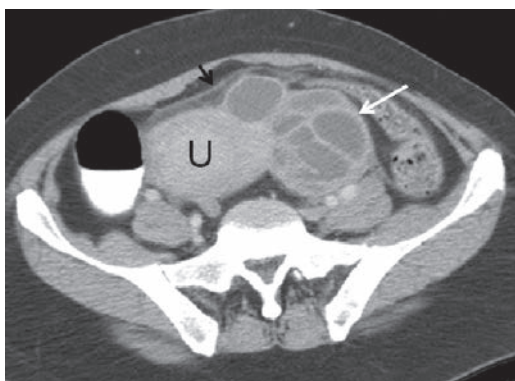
A 40-year-old woman with cervical cancer presented with fever, left lower quadrant pain and diagnosed with tubo-ovarian abscess. Axial contrast enhanced CT scan demonstrates a complex multiloculated mass with thick septations (white arrow) to the left of the uterine fundus (U). There are inflammatory changes in the pelvic fat (black arrow).
